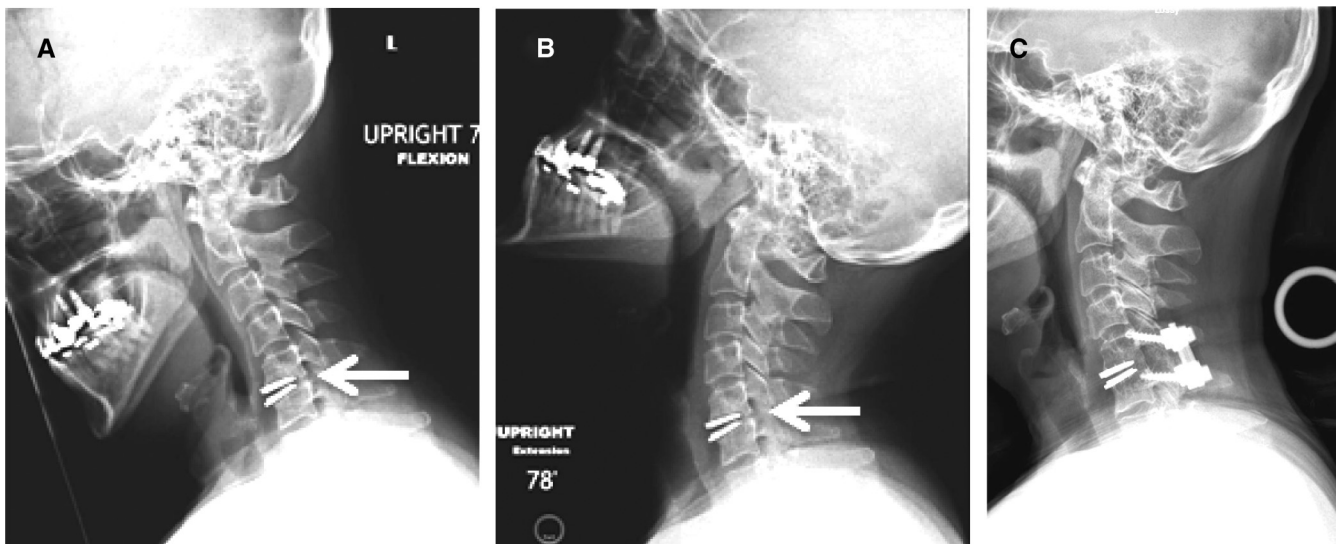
The same patient as in Figure 5 re-presented at 3-year follow-up with recurrent cervical radiculopathy. Lateral flexion (A) and extension (B) C-spine x-rays showed anterior migration of the graft resulting in posterior disk space collapse and recurrent neuroforaminal stenosis. C, a C5-6 posterior instrumented fusion with lateral mass screws was performed to reopen the neural foramina at that level.
